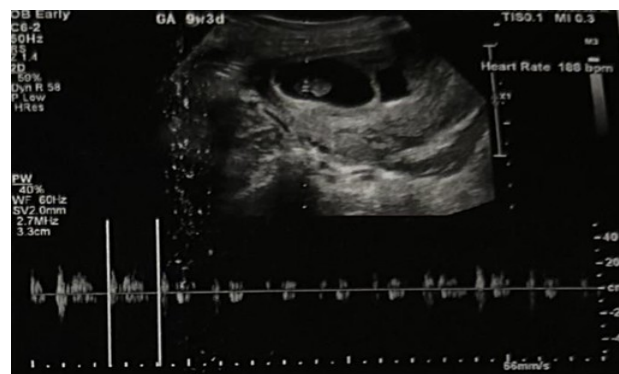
Transabdominal ultrasound showing single live fetus with good cardiac activity
